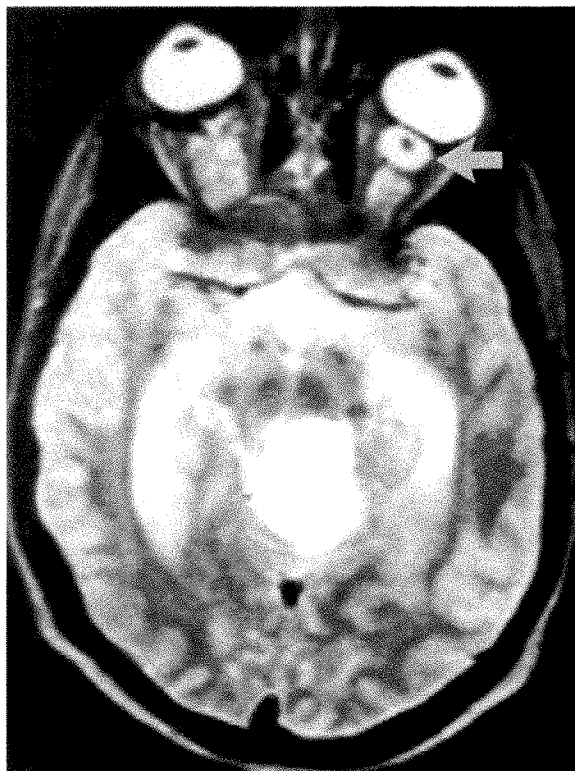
(Imes and Hoyt). Case 1. Preoperative T_2 -weighted axial magnetic resonance image shows a large mass in the posterior fossa with high signal intensity and dilated lateral ventricles. Anteriorly in the left optic nerve, a thick rim of high signal intensity surrounds a core of lower signal intensity (arrow).
